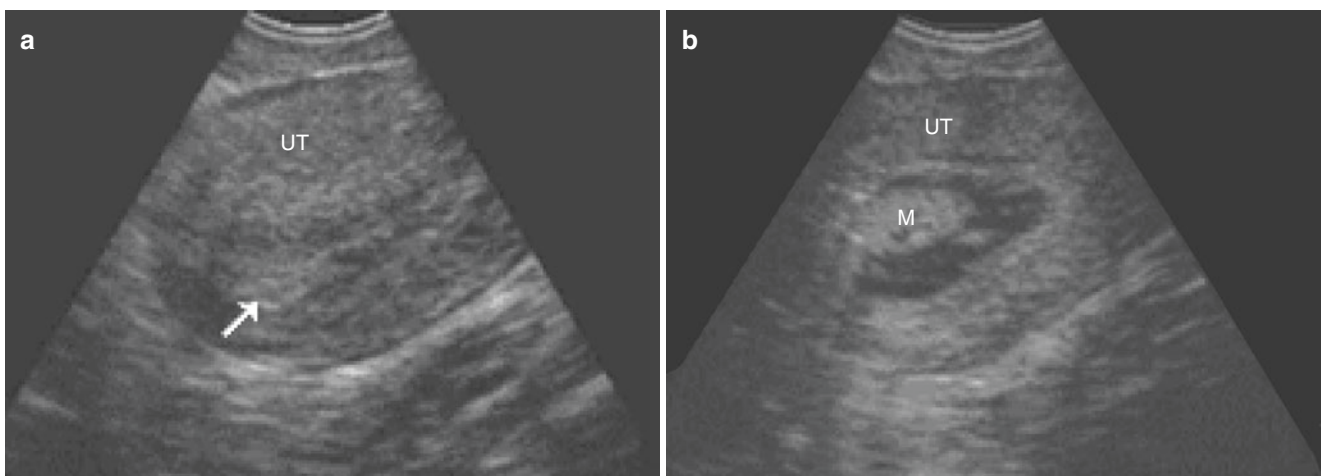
Sonohysterography of single endometrial polyp (II) (a). A vaginal ultrasound examination of a 33-year-old woman shows thickening and inhomogeneous endometrium, (b). After injection of contrast
